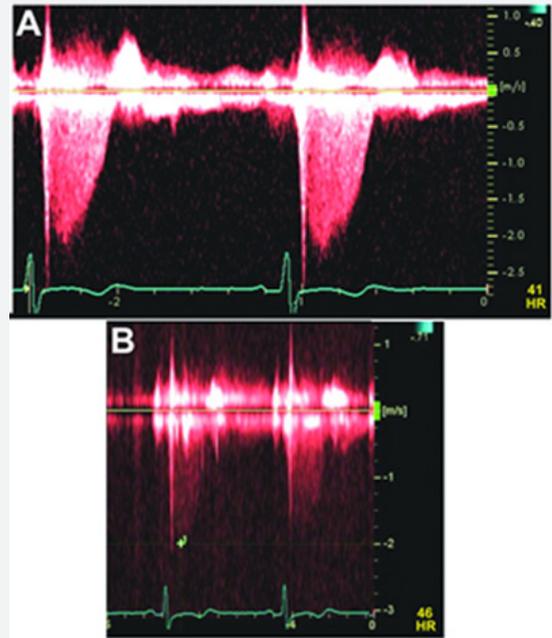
Continuous wave Doppler of tricuspid valve in patient #1(A) and patient #2(B).
